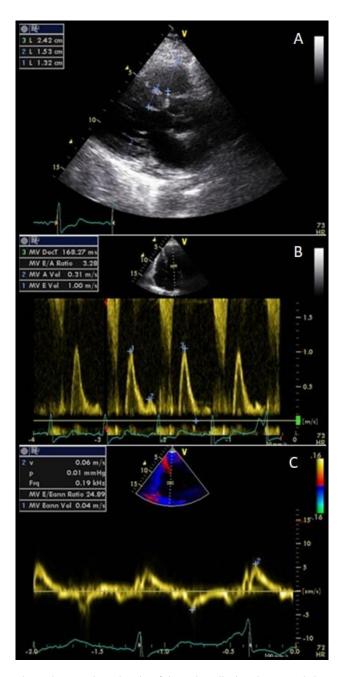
The transthoracic echo of the patient displayed concentric hypertrophy of the walls of the left ventricle (A), with hypokinesia of the apical intraseptum and the apex, slightly to mildly impaired systolic function, left atrium enlargement and a restrictive-like filling pattern (B,C).
